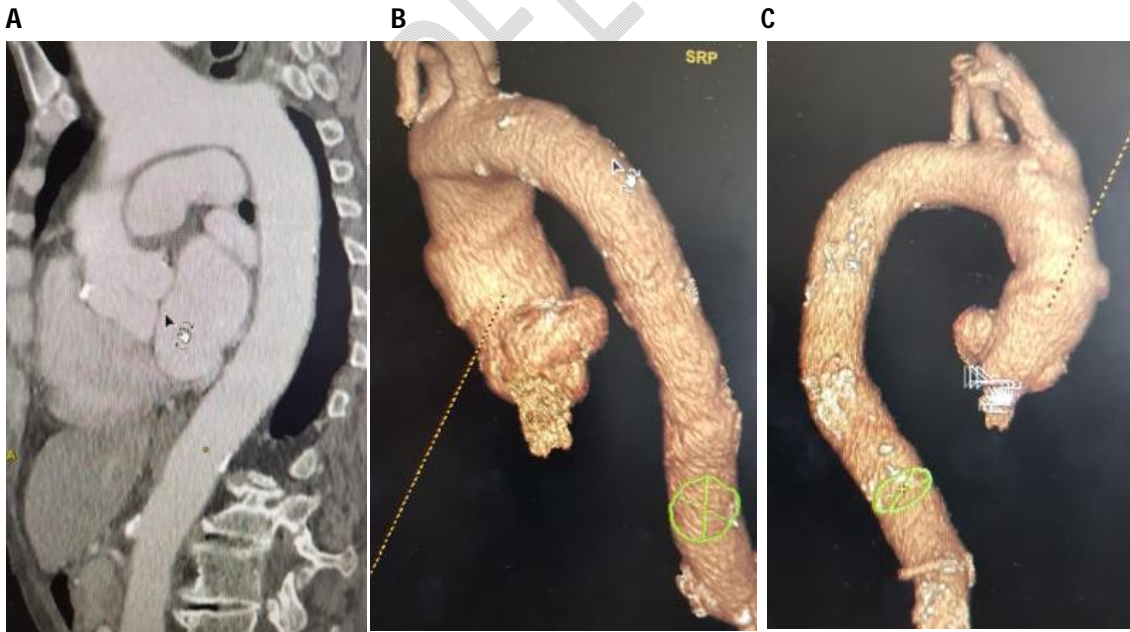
shows a saccular aneurysm at the level of the initial part of the ascending aorta (A: CT angiography image, B and C: 3D aortic construction showing the localization of the aneurysm).
